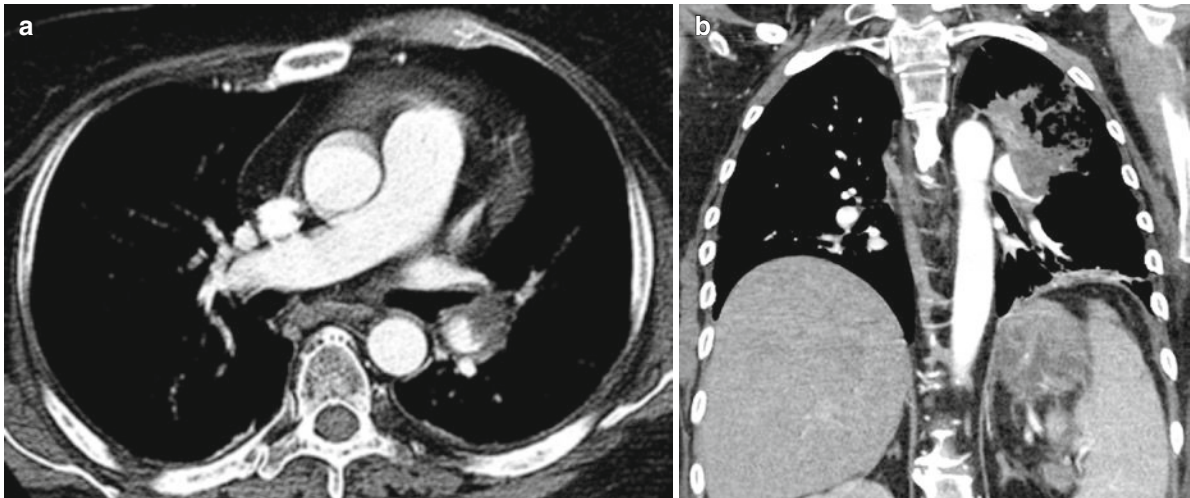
A 45-year-old patient with acute myelogenous leukemia and a history of unrelated peripheral blood stem cell transplantation 6 months earlier. Contrast-enhanced CT demonstrating
